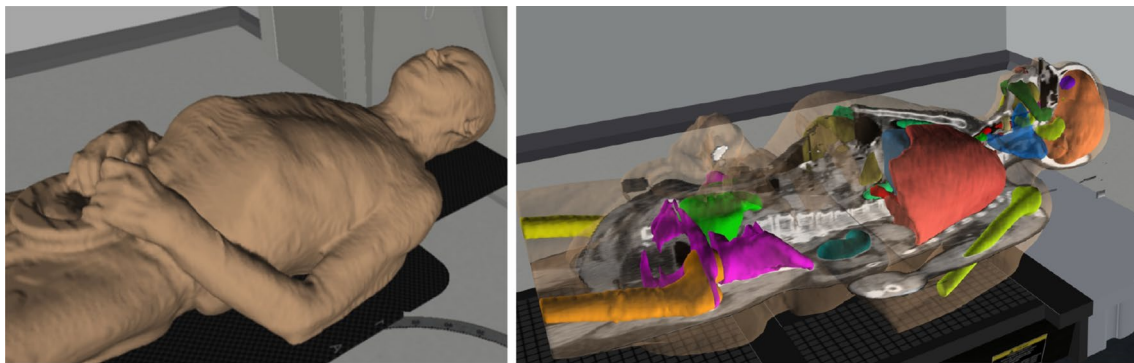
Screenshots from the “(CT) Anatomy for physicists” VERT tutorial, showing the patient’s external view (left) and the internal anatomy shown as 3D volumes and CT images (right)
